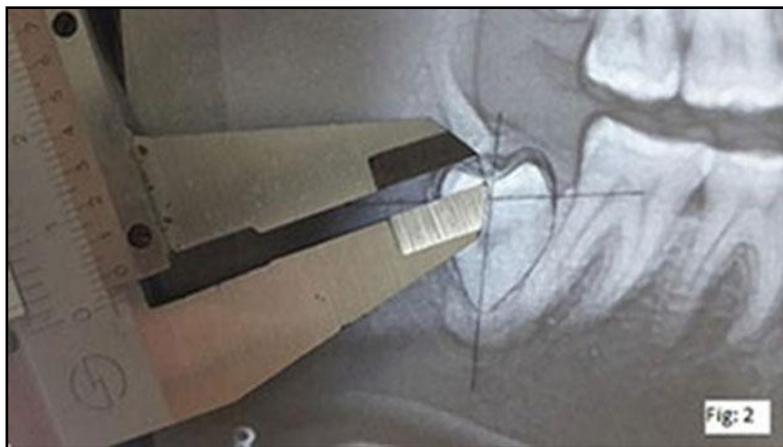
Method of measurement of follicular space by tracing panoramic radiographic image of IMTM on tracing paper
